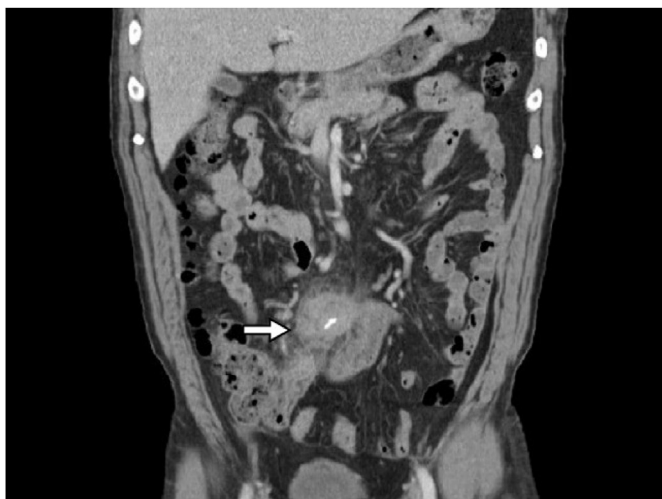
Coronal view on contrast-enhanced computed tomography shows a spiculated mass with central calcification (arrow), connected to the cecum, and compatible with perforated appendicitis.
